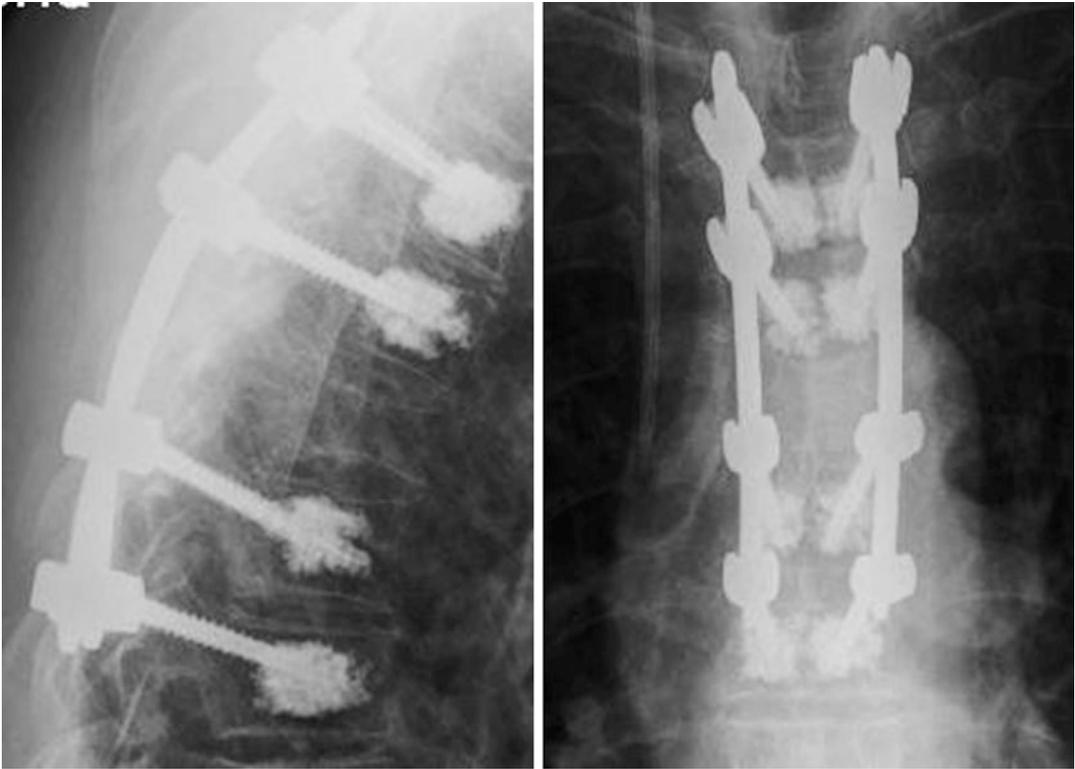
Postoperative lateral (left) and a.p. (right) standing radiography confirm correct placement of the instrumentation system
